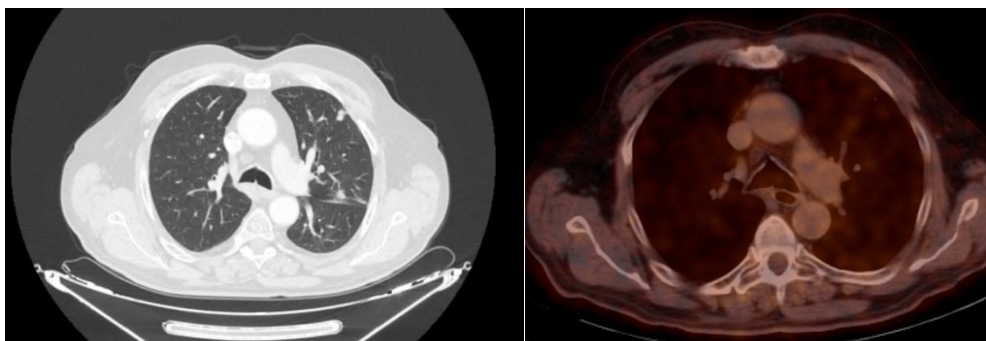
CT and PET-CT fusion images of a subsolid nodule in the right lower lobe
